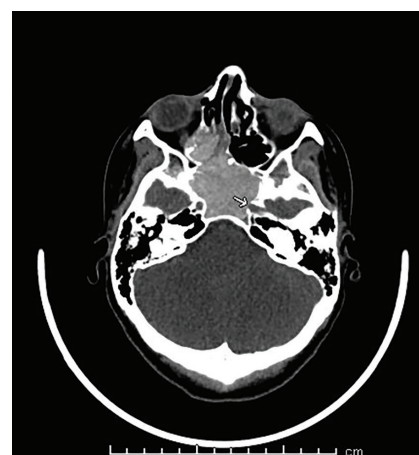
Transverse-view maxillofacial CT image without contrast showing homogeneous opacification of hyperdense material filling the ethmoid and sphenoid sinuses.
